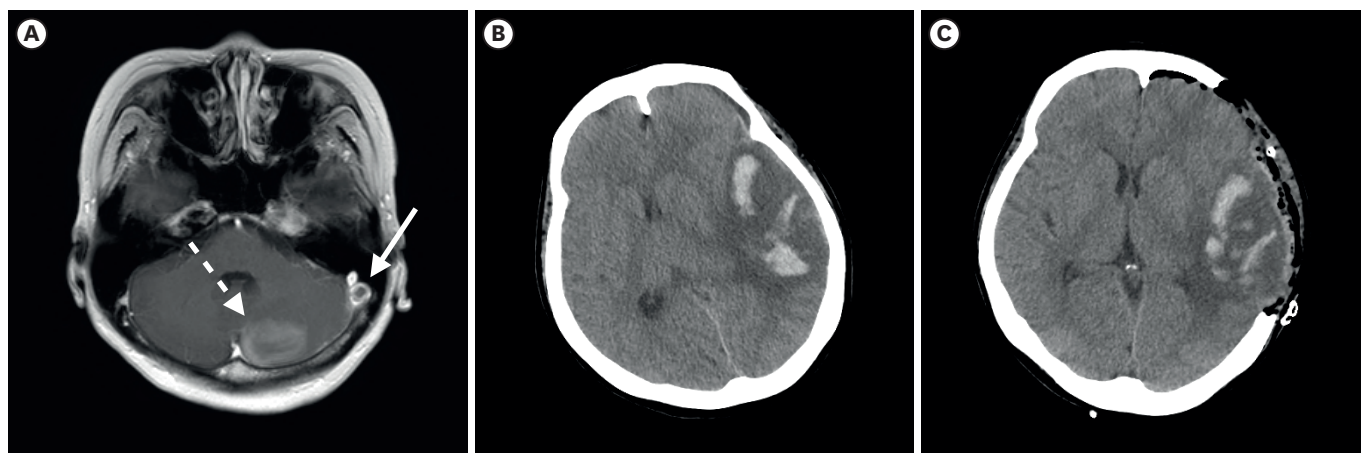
Initial preoperative and postoperative brain image following craniectomy. (A) Axial image of contrast enhanced brain magnetic resonance imaging shows an empty delta sign in left sigmoid sinus (white arrow) and acute infarction in the medial side of the left cerebellum (white dotted arrow). (B) A brain CT scan shows a large intracerebral hematoma in the left temporo-parietal lobe along with mass effect and midline shifting toward the right side. (C) A brain CT after craniectomy shows restoration of the midline shifting. CT: computed tomography.
